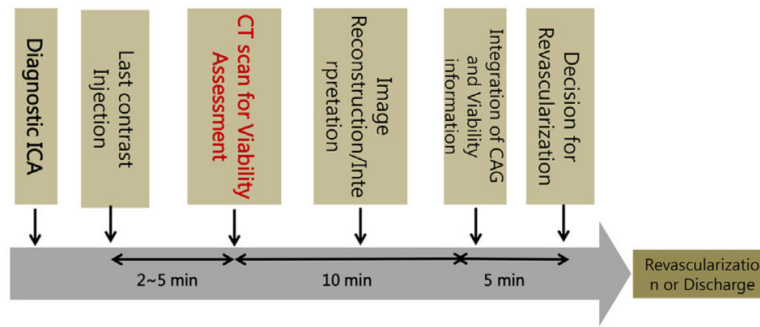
Conceptual framework of viability assessment using a cardiovascular interventional therapeutic CT system in a patient with suspected coronary artery disease and severe left ventricular dysfunction. ICA, invasive coronary angiography.
